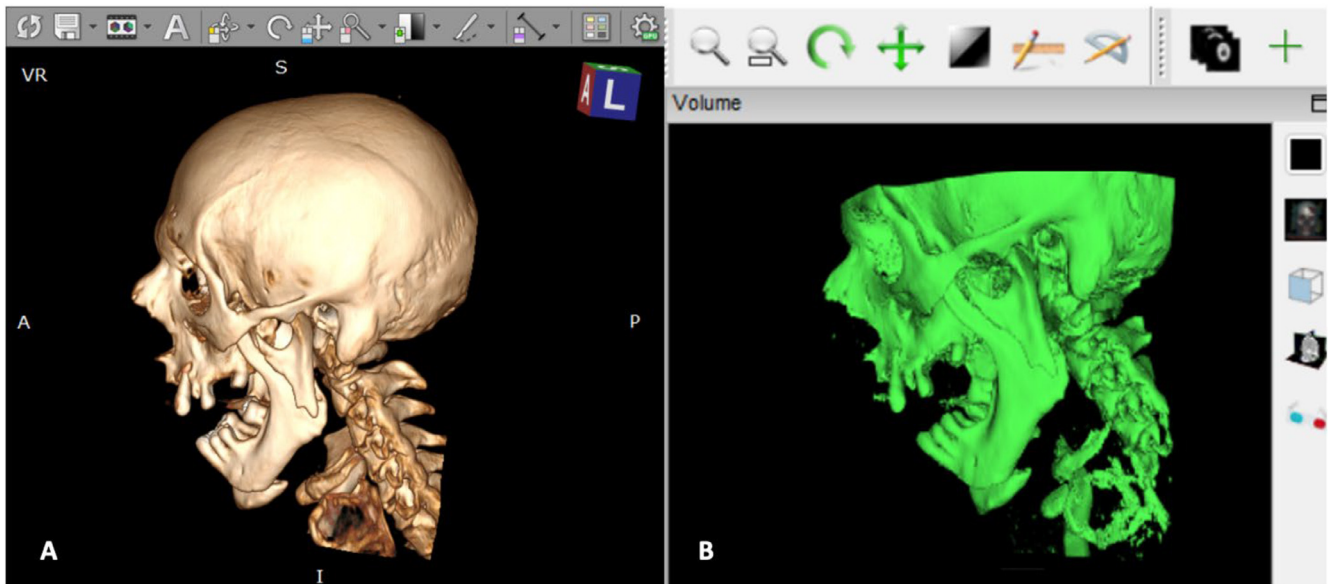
Pre-operative 3D CT image in DICOM files: (a) Visualization with the RADIANT viewer 64bit software; (b) Visualization with InVesalius 3.1 software.
